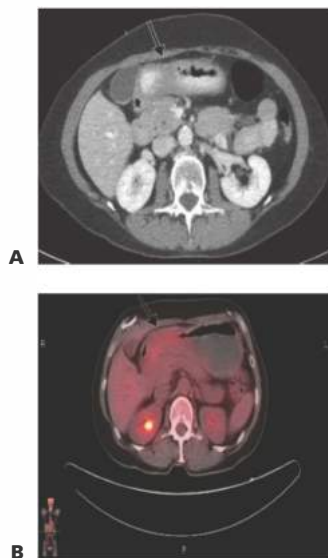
• Cross-sectional imaging in the form of CT and CT/PET helps to evaluate for distant metastatic disease as well as extent of locoregional disease. A. CT scan in a patient with gastric cancer demonstrates thickening of the gastric antrum with nodularity in the gastrocolic ligament suggestive of direct spread to the transverse colon. B. PET/CT corroborated with CT scan to suggest involvement of gastrocolic ligament. No metastatic disease was observed.
